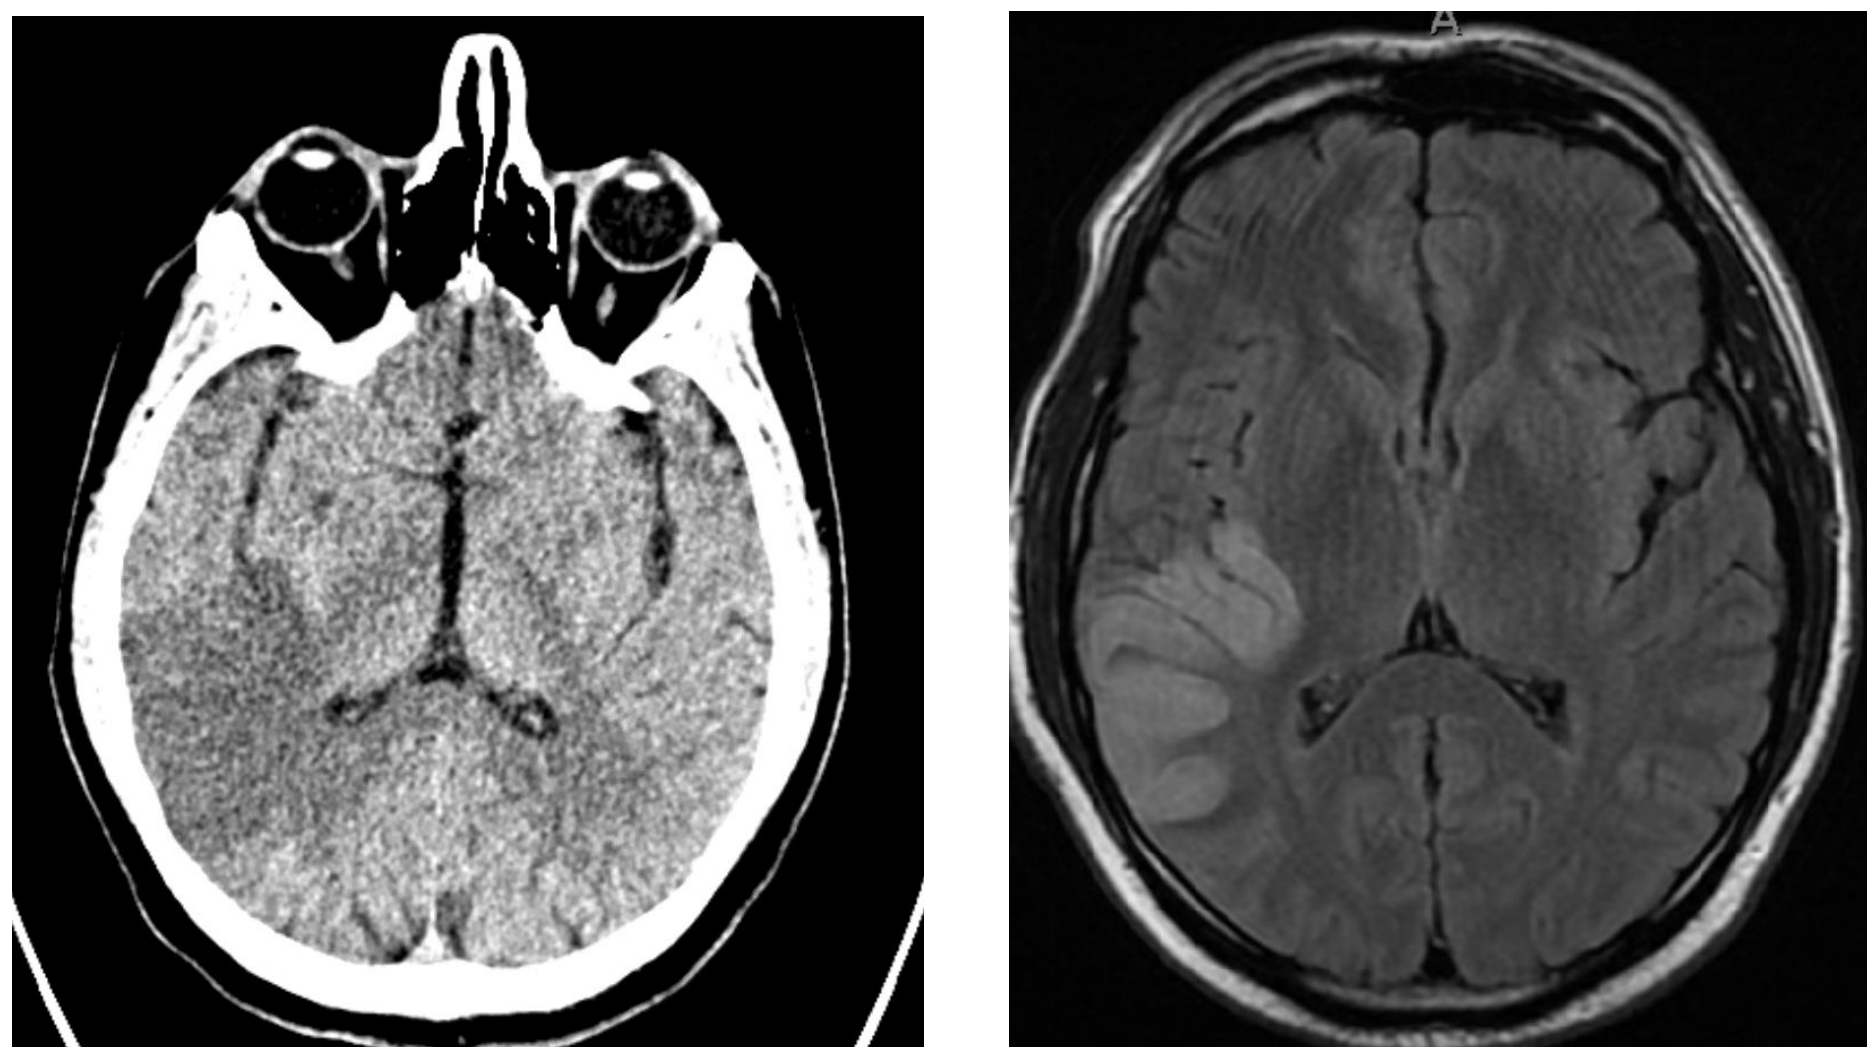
(Left) CT Head showing large hypodensity in temporoparietal-occipital region consistent with acute infarct of right MCA territory. (Right) Corresponding MRI Brain on T2 axial imaging.
